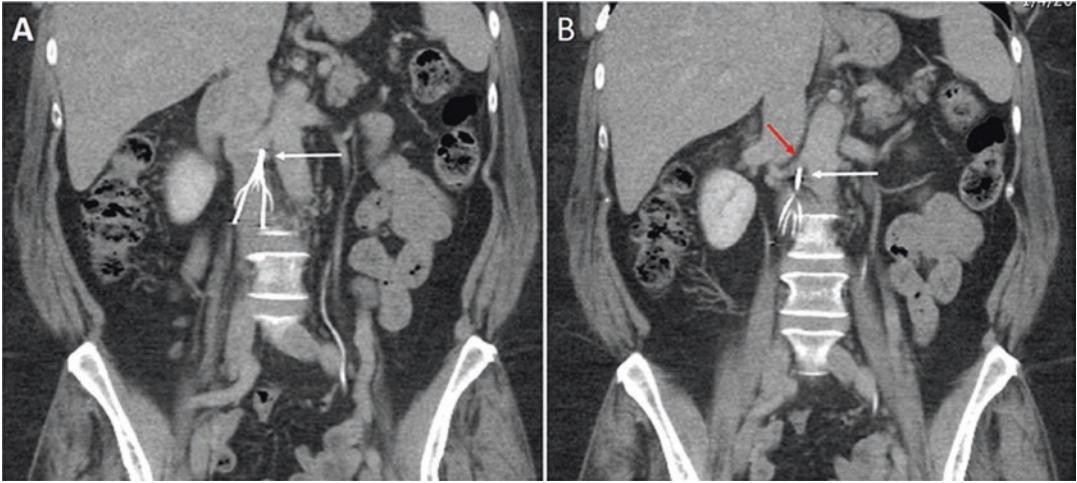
Coronal reconstruction of CT scan demonstrating a tilted IVC filter with the hook (*white arrow*) eroding through the wall of the cava. (*a*) The next CT cut shows the hook of the filter abutting the origin of left renal artery (*red arrow*) (*b*)
